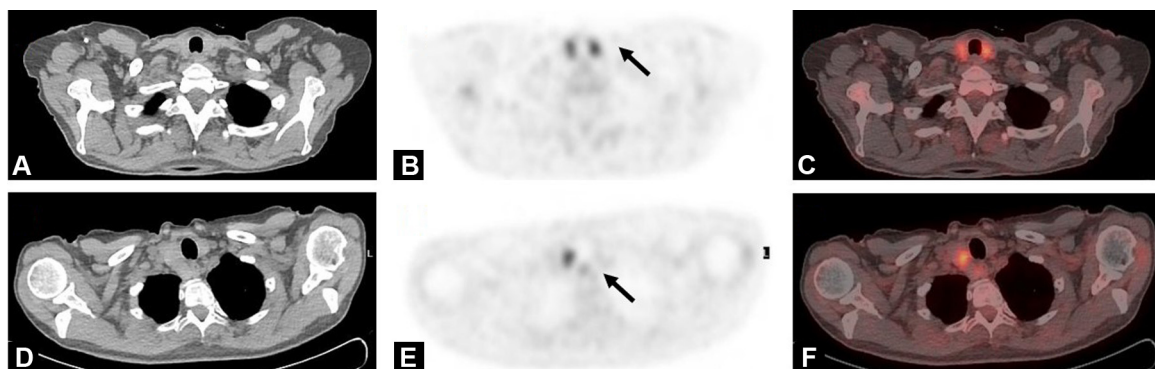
Representative example of diffuse (A, B, C) and focal (D, E, F) uptake pattern at ^{18}F -FDG positron emission tomography/computed tomography (PET/CT) imaging.
